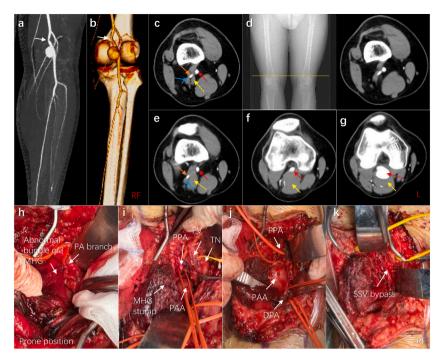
Images of the PAES patient during diagnosis and treatment procedure. (a, b) Aneurysm of the right popliteal artery (PA) on computed tomography angiography (CTA). The stenosis of PA was shown by white arrows. (c–g) The axial images showed the abnormal muscle bundle and popliteal artery aneurysm (PAA). The yellow line in d show the position of this muscle bundle originating above the medial condyle of the femur. Red arrows show PA. Yellow arrows show the medial head of the gastrocnemius muscle (MHGM), the dotted ones of which shows the abnormal muscle bundle. The orange arrow shows the branch of PA. The blue arrows showed popliteal vein (PV). (h–k) Intraoperative photographs showing the abnormal bundle of MHG, proximal PA (PPA), distal PA (DPA), PV, tibial nerve (TN), and small saphenous vein (SSV).
